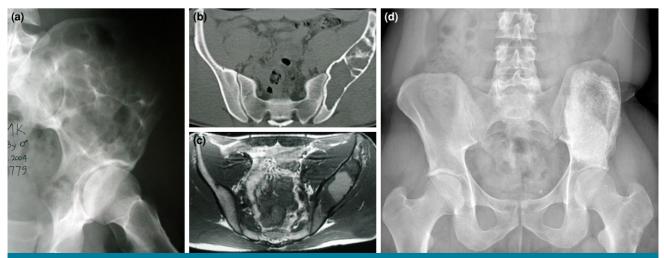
A 23-year-old male with CMF in the left ilium (a) preoperative radiogram; (b) preoperative axial CT section; (c) preoperative T2 weighted axial MRI section). Curettage and cementing was applied. (d) shows postoperative radiograms at 12 months.
